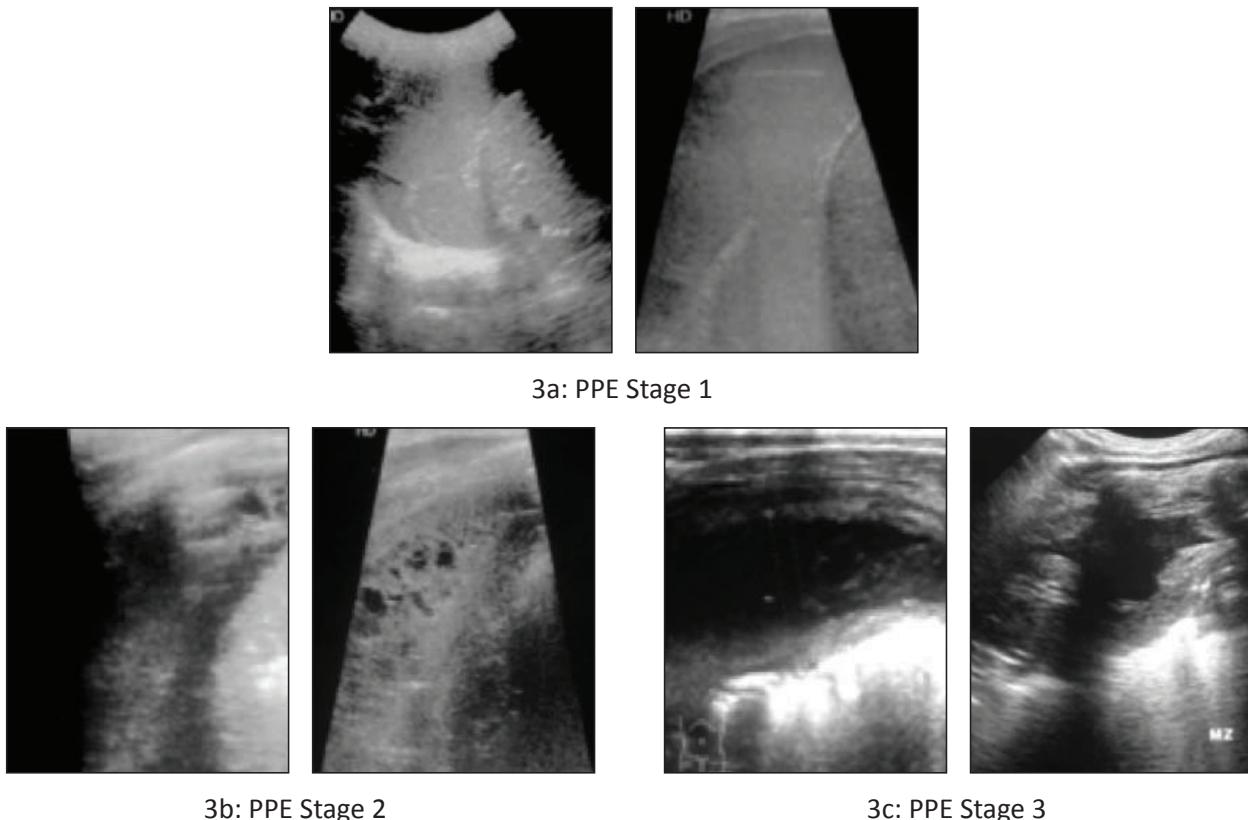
Stage of Para-pneumonic Effusion (PPE) by ultrasound Thorax
